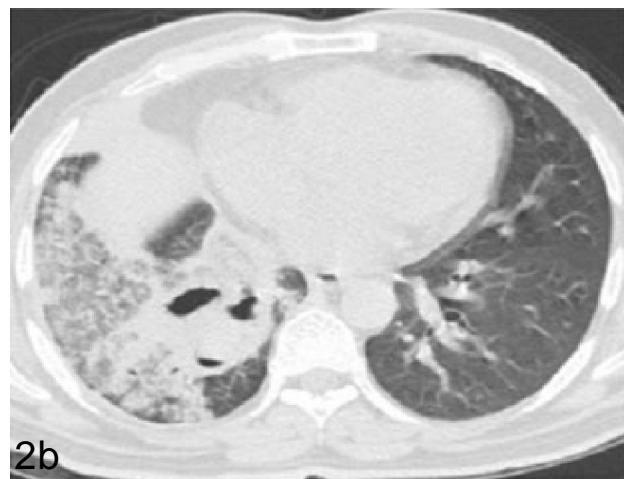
Plain CT thorax in mediastinal and lung window respectively showing dense consolidation with cavitation in apical and basal segments of right lower lobe.
